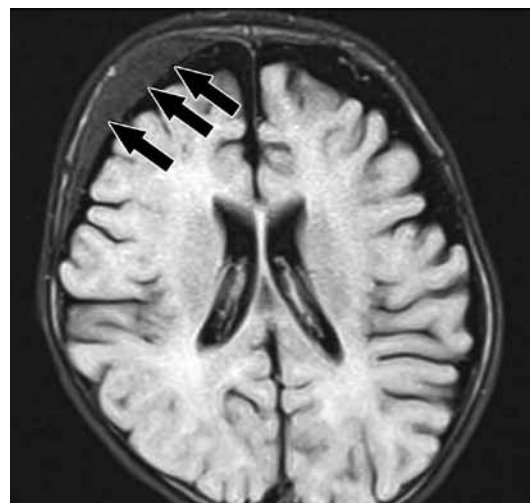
Axial MRI brain (FLAIR), showing right subdural hematoma (arrow).
